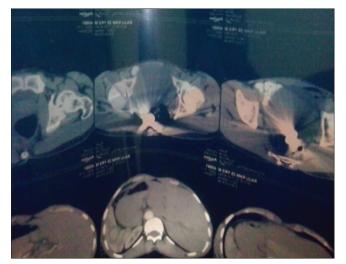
Metallic foreign body seen in contrast-enhanced computed tomography pelvis
